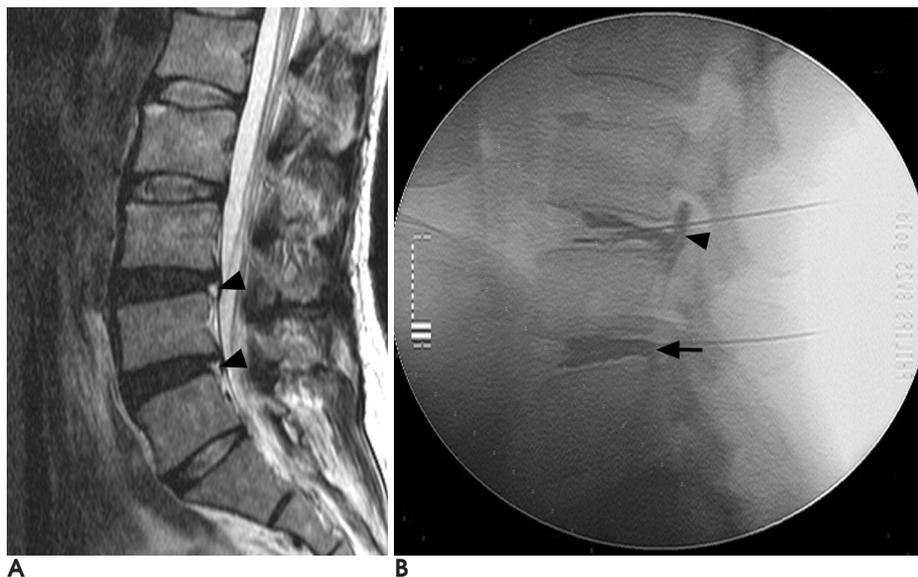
MR image of the lumbar spine and discogram at the intervertebral levels of L3-L4 and L4-L5 in a 40-year-old woman.
